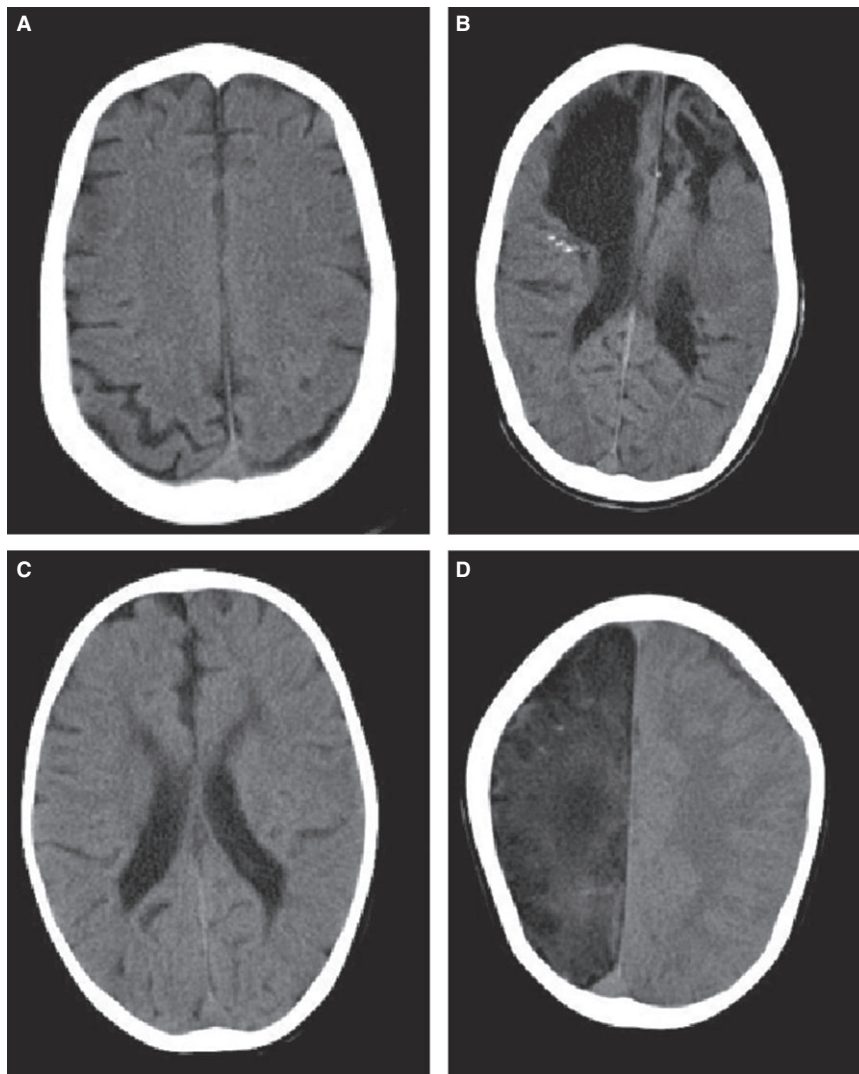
Examples of the computed tomography (CT) scan findings in the studied children with Cerebral palsy. (A) Primary grey matter injury. Precontrast CT scans of a four-year-two-months-old girl who presented with left unilateral spastic cerebral palsy (CP) and epilepsy. The cortical sulci are wider than normal, further supporting the diagnosis of diffuse cortical atrophy. Images show a very thick skull bone, which is indicative of arrested brain growth. The right sylvian fissure is wider, but no obvious focal brain lesion is evident. This child was on sodium valproate tablets for her epilepsy, and while some anti-epileptic drugs have been shown to interfere with bone mineral density, she had low serum magnesium levels, which could explain this thick skull. In addition, she had no features of malnutrition, had normal serum calcium and phosphate levels and did not have chronic iron deficiency anaemia. We were, however, not able to rule out sickle-cell anaemia or thalassaemia. (B) Heterogeneous white and grey matter damage. Precontrast CT scans of a nine-year-old boy who presented with bilateral spastic CP. Images show destructive lesions in both frontal lobes, more extensive on the right side. There is also extensive bilateral parietal damage with calcifications in the periventricular area, and cyst formation suggestive of end stage brain damage following an intrauterine infection with CMV or toxoplasmosis late during the third trimester. The child was born at home with the assistance of a traditional birth attendant. The mother denied any history of infection during pregnancy or after birth. (C) Primary white matter injury. Precontrast CT scans of a two-year-eight-months-old girl, born preterm (more than three weeks before expected date of delivery), who presented with dyskinetic CP, microcephaly and a bilateral talipes equinovarus deformity. Mother reported she had bleeding on several occasions throughout the pregnancy, a history of fever and infection in the 1st trimester. The child was admitted to hospital after birth for four days and managed for suspected infection and seizures. Images show signs of mild cerebral atrophy and severe loss of periventricular white matter. Grey matter close to trigone abuts the ventricular wall and slightly indents the ventricular wall. This appearance is very typical of white matter damage of Immaturity, previously known as periventricular leukomalacia – PVL. (D) Focal cortical infarction. Precontrast CT scans of a four-year-three-months-old girl who presented with left unilateral spastic CP. Images show total destruction of the entire right cerebral hemisphere with a normal left hemisphere suggestive of a probable late occlusion in the entire right carotid artery system. Note also the reduced size of the right hemicranium.
